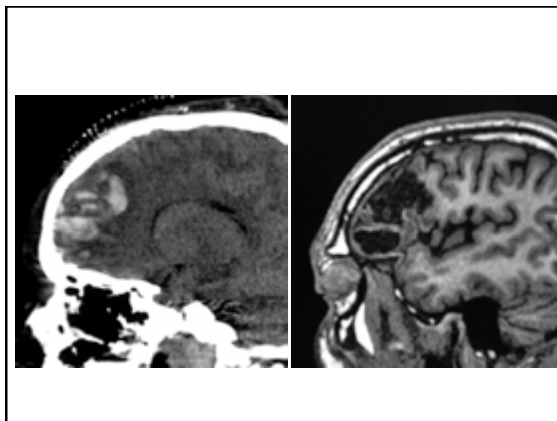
Clinical example Argemiro CT series showing Argemiro's frontal abscess.
